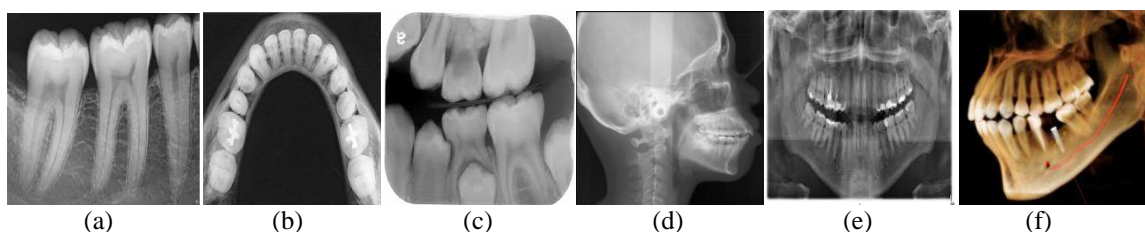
(a) Intraoral Periapical, (b) Occlusal x-rays, (c) Bitewing, (d) Extraoral X-rays, (e) 2D Panoramic, (f) 3D CBCT image
